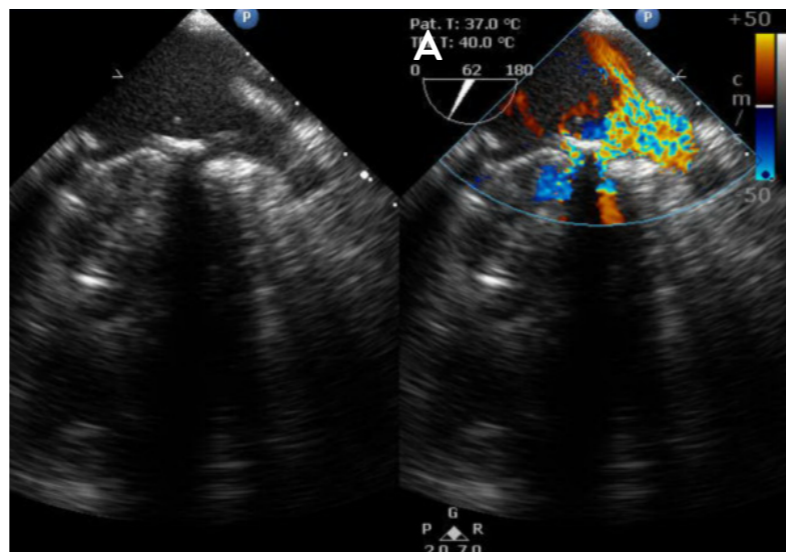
Pre-procedural Transoesophageal echocardiography and colour doppler (A) showing a large paravalvular leak and following closure (B) with 2 AVP III devices
